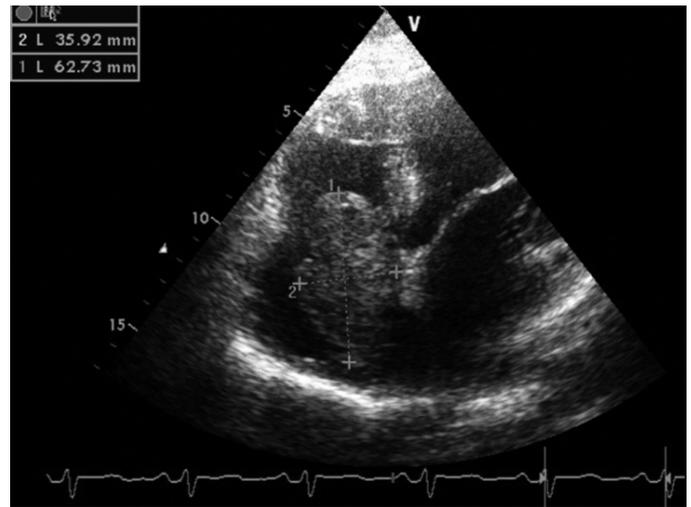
Apical four chamber view demonstrating free-floating thrombus in the right atrium (62x35 mm).
